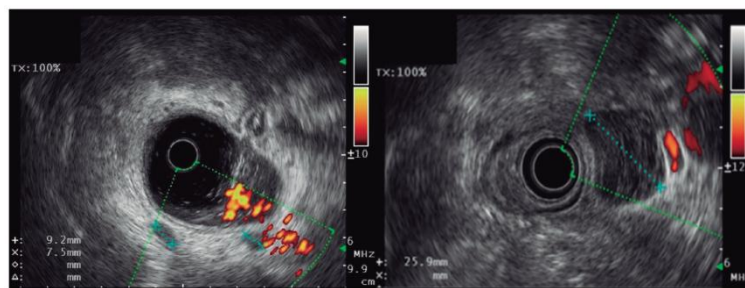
Endoscopic ultrasound assessment of regional lymph nodes in rectal tumors
